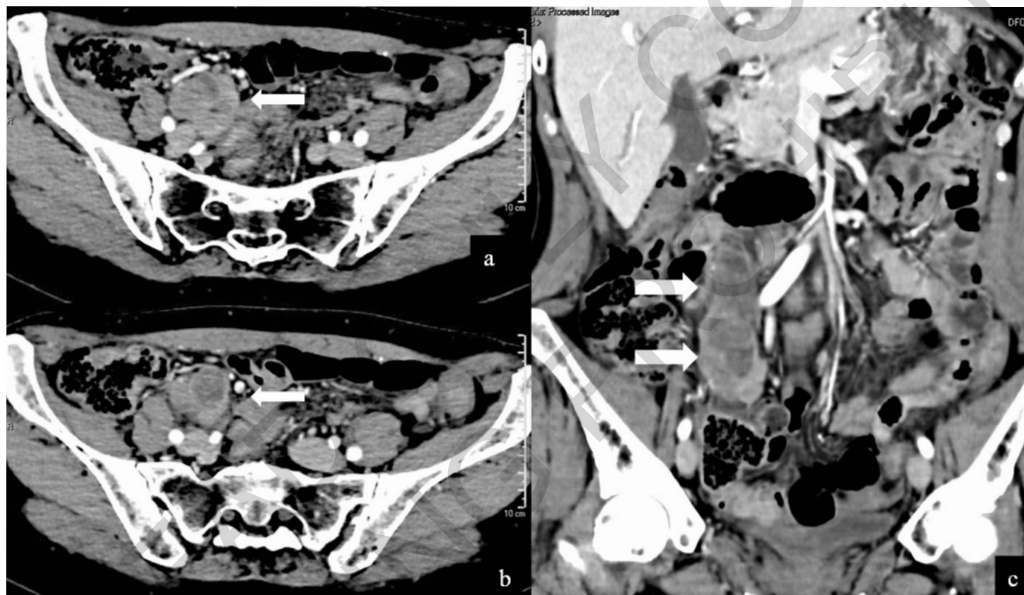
Leiomyosarcoma of the gonadic vein. Axial (a and b) and MPR coronal (c) contrast enhanced CT images reveal an heterogeneous mass developing along the right gonadic vein (arrows).
